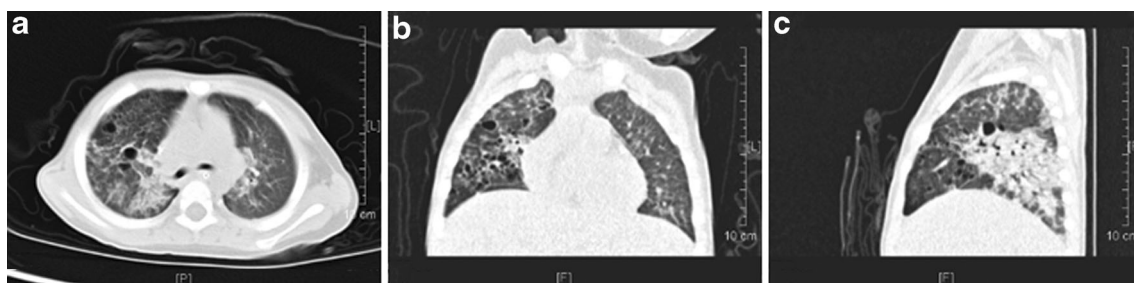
Lung windows from high-resolution CT scan of the chest on the day of admission revealing many cystic images and consolidation in the right lobe in a 3-y-old child with acute ELP
